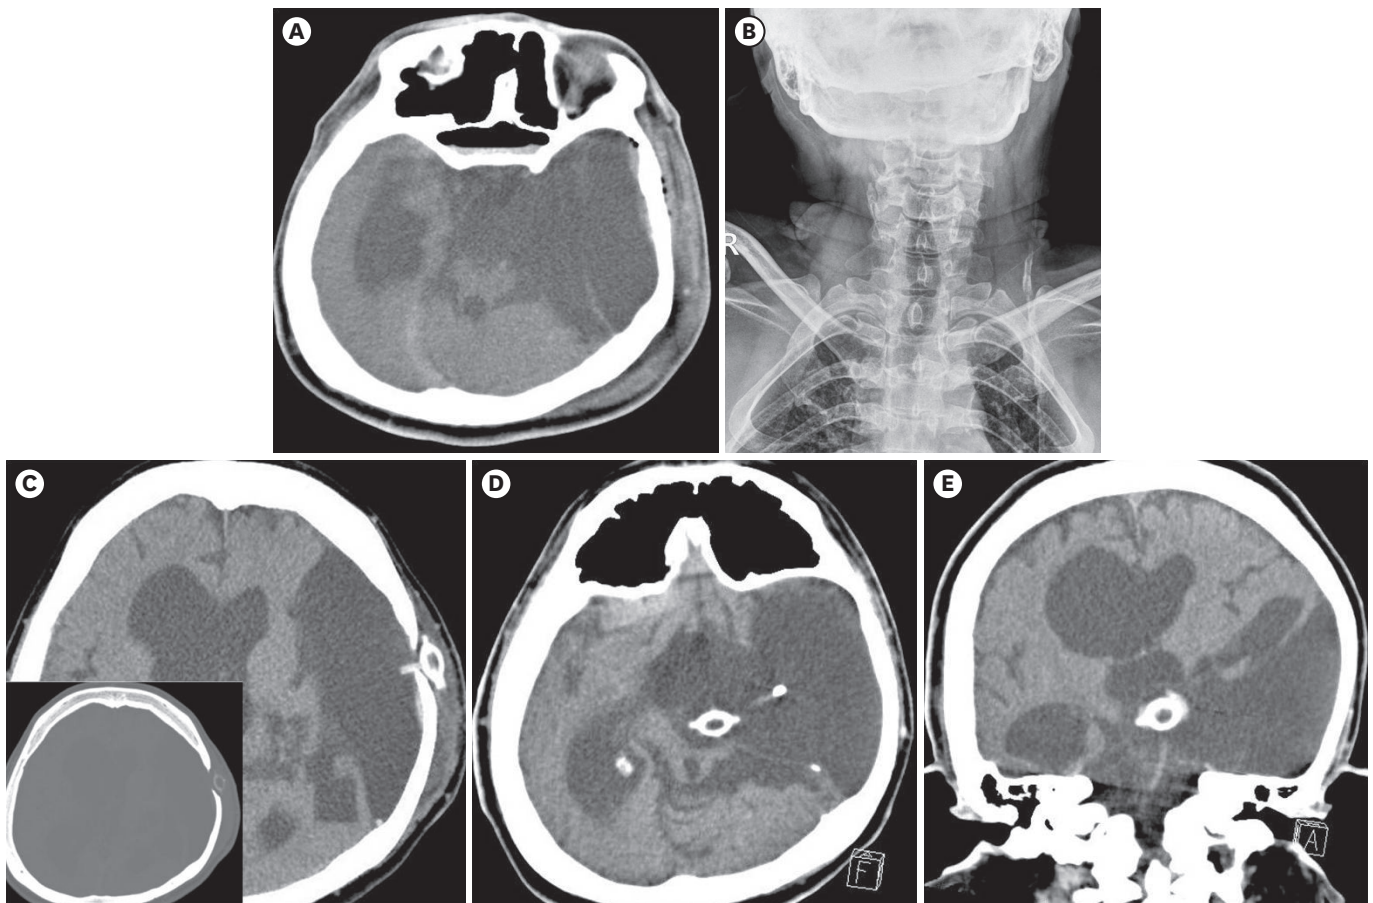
Traumatic migration of a shunt valve into the cranium. (A) Head scan shows acute hemorrhages in the epidural and subdural space with minimal pneumocephalus. There is a scalp contusion over the left side of the head. (B) Neck X-ray reveals a calcification and fragmentation in the disconnected distal shunt tubing. (C) This section depicts the burr hole-type reservoir to be in the correct position. (D & E) The size of the perforation is larger than the base of the device in the inset. Note the valve migrating into the deep portion of the cyst at the second admission.
